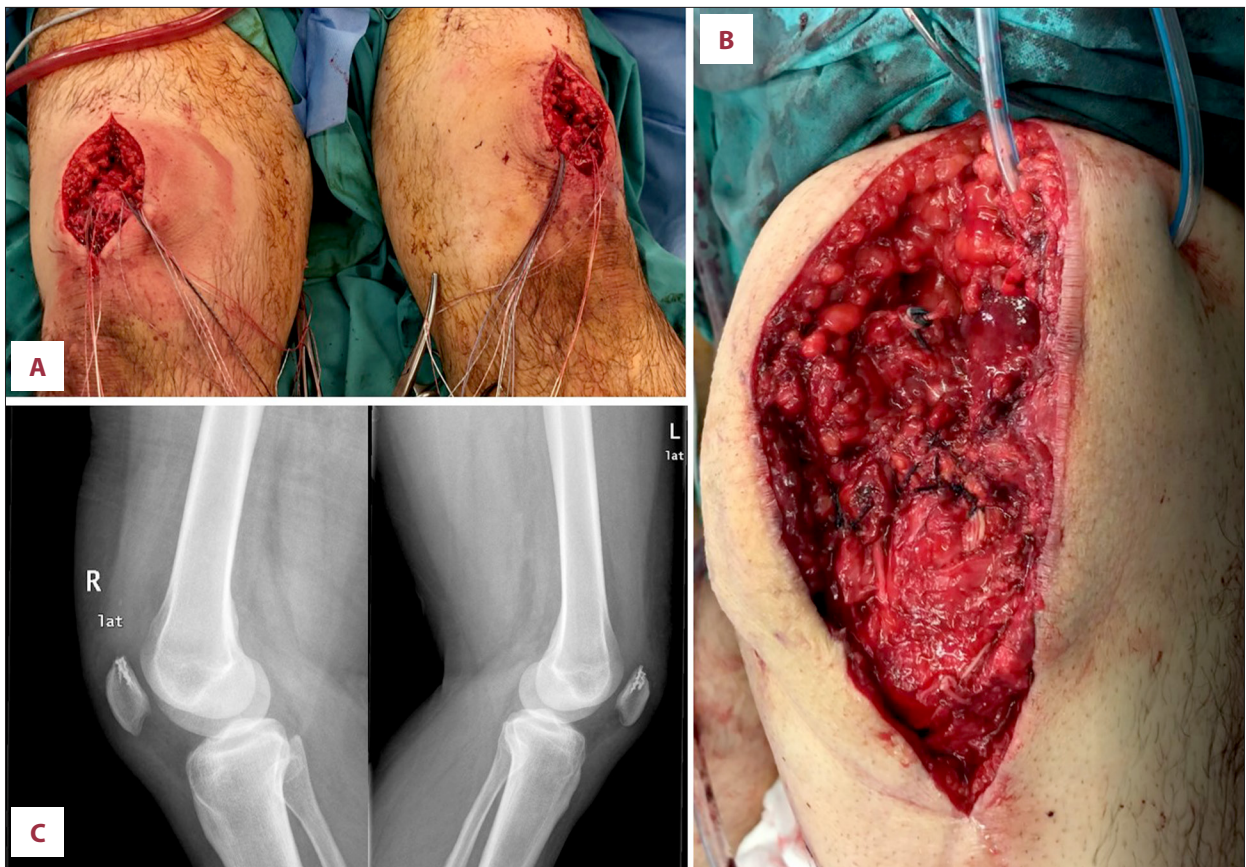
(A, B) Intraoperative picture showing the application of bone anchors in the upper pole of the patella in both knees and the final repair in the left side, (C) postoperative lateral radiographs showing the position of the anchors and the corrected patella height.
